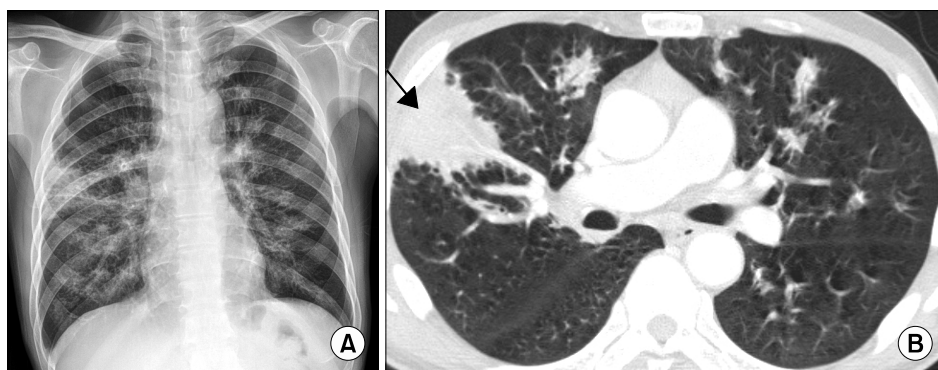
(A) Chest radiograph shows multifocal patchy consolidations in both lungs. (B) Chest computed tomography demonstrated bilateral infiltrations along the bronchovascular bundles (arrow).
